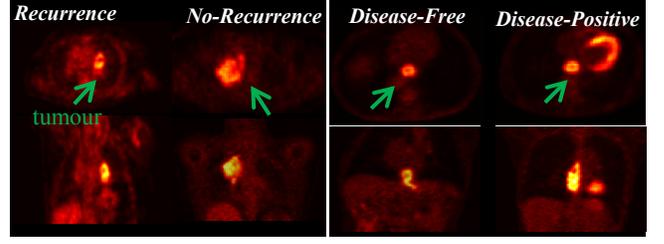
Example tumour uptakes on FDG-PET imaging from different views; (a) recurrence and no-recurrence instances before treatment of lung tumour; (b) disease and disease-free instances before treatment of esophageal tumour.
